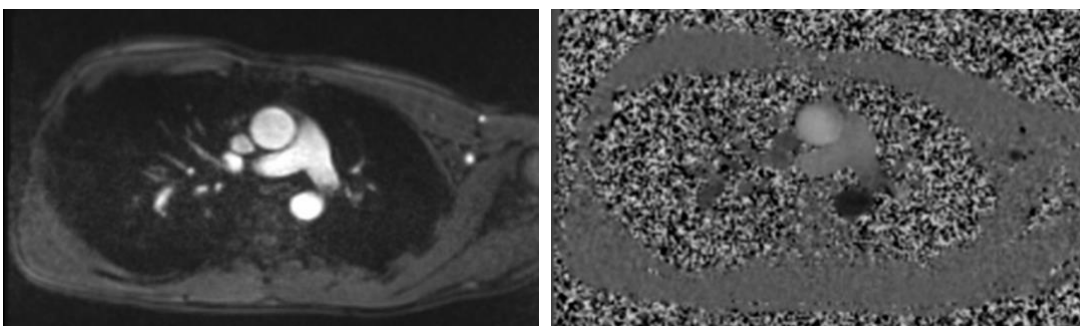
Phase-contrast MRI of the ascending aorta.
